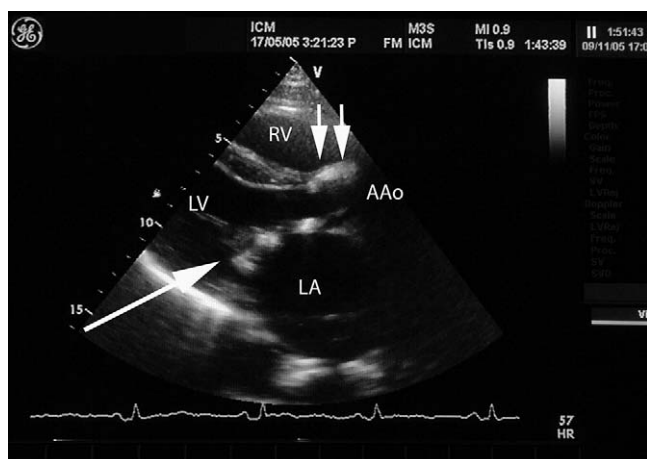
Transthoracic echocardiography showing Freestyle No. 25 bioprosthesis in the aortic position 10 years after implantation (arrowheads). RV, Right ventricle; LV, left ventricle; LA, left atrium; AAo, ascending aorta.
